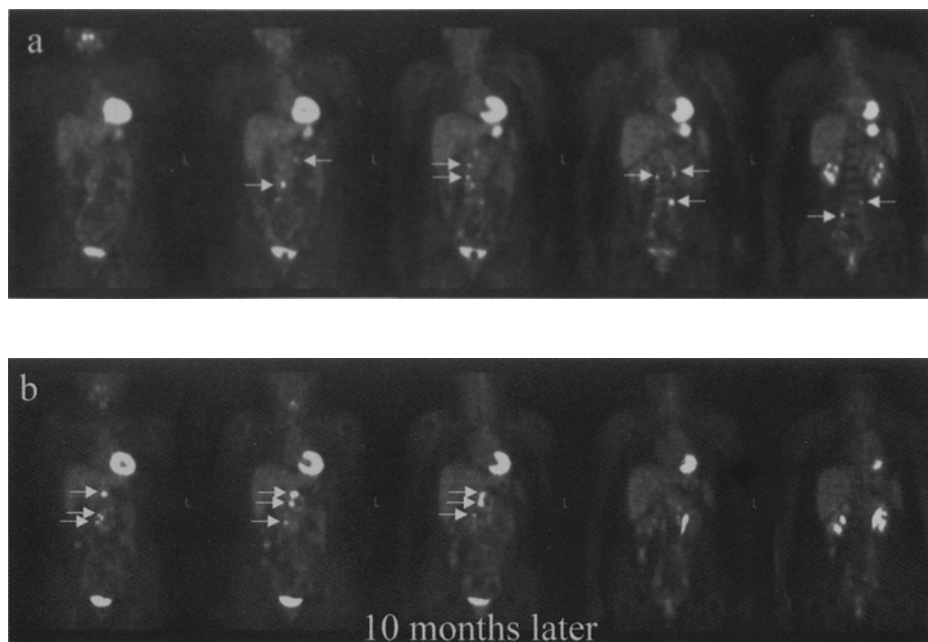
Serous papillary adenocarcinoma, initial stage IIIc (#16). The first FDG-PET, examined when the patient had a high serum CA125 level and was diagnosed as recurrence by CT and MRI, showed multiple uptakes (*white arrows*) in the abdomen suggesting LN metastases (a). She received repeated systemic chemotherapy and also radiation therapy to the LN metastasis invading the 4th lumbar vertebra. The second FDG-PET, examined 2 months after the last treatment to evaluate the treatment response, showed decreased FDG uptake in the lower abdomen and pelvis suggesting a therapeutic effect, but also showed increased FDG uptakes (*white arrows*) in the upper abdomen (lymph node metastases) which was outside the field of radiation therapy (b).
